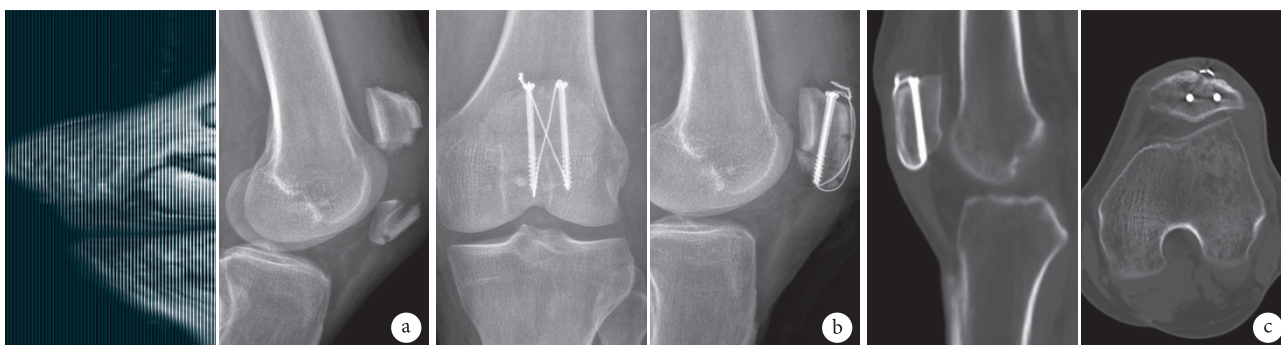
对照组患者,男,53岁,左髌骨粉碎性骨折 a. 术前 CT 及侧位 X 线片; b. 术后即刻正侧位 X 线片; c. 术后 1 年 CT
